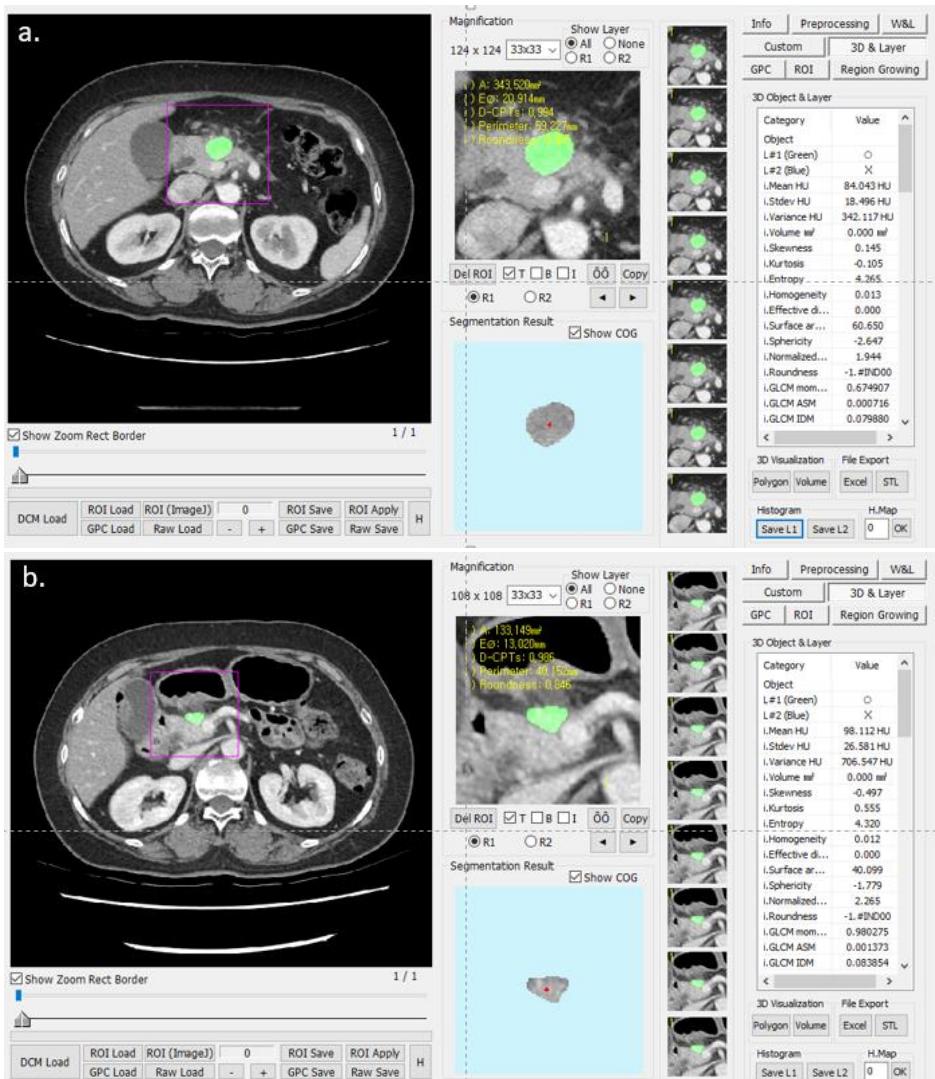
Segmentation and their texture feature was extracted from baseline and preoperative CT images. Subtracted value of entropy of pancreas head cancer was 0.0554 and subtracted value of GLCM entropy was -0.3983. Overall survival of a 52-year-old man was 35.3 month, longer than median survival.
